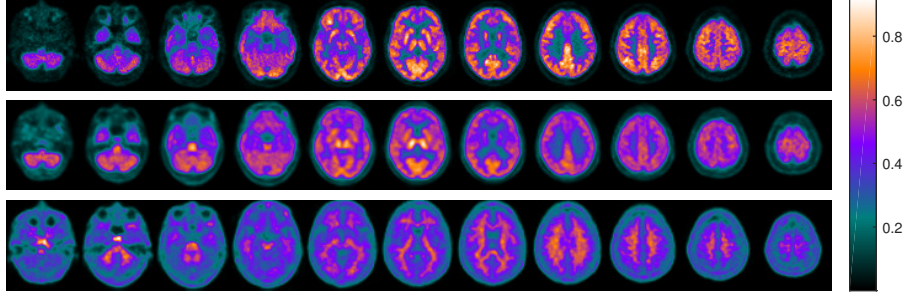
Comparison of the three neuroimaging modalities used in this work. Axial slices from a FDG (top), eFBB (middle) and sFBB (bottom) neuroimage are shown. The three neuroimages correspond to the same patient, who was diagnosed with AD.
